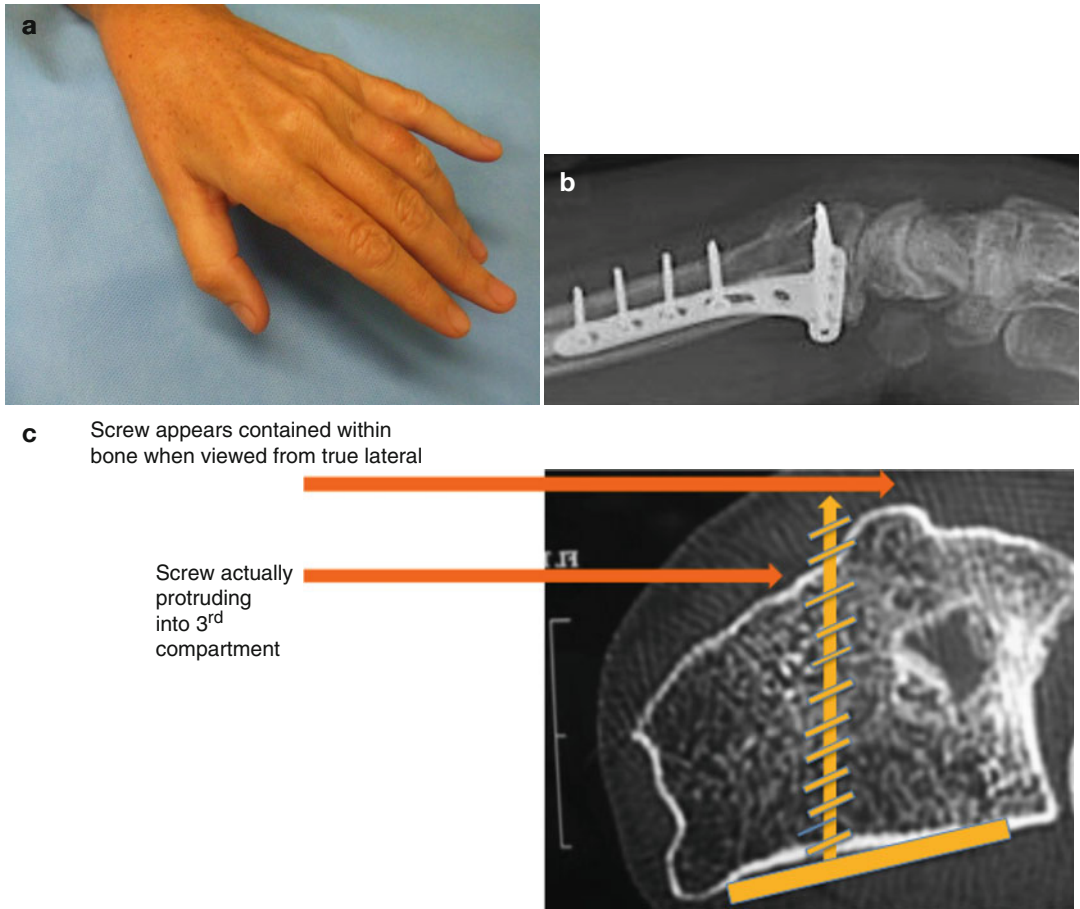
(a) EPL rupture; (b) parallax error on lateral radiograph; (c) oblique radiograph showing long screw impinging in third compartment
